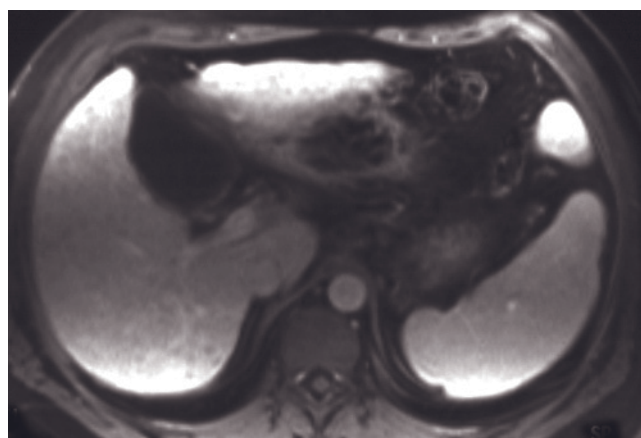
Cirrhosis with high-grade dysplastic nodule. T2-weighted SS-ETSE (a), SGE (b), and immediate (c) and 45-s (d) postgadolinium SGE images in a cirrhotic patient. A high-grade dysplastic nodule is appreciated at the junction between segments 8 and 5, which demonstrates mildly high signal intensity on T2 (a), isointensity on T1 (b), and intense homogeneous enhancement on early-phase image (arrow, c) that fades on 45-s image (d).
